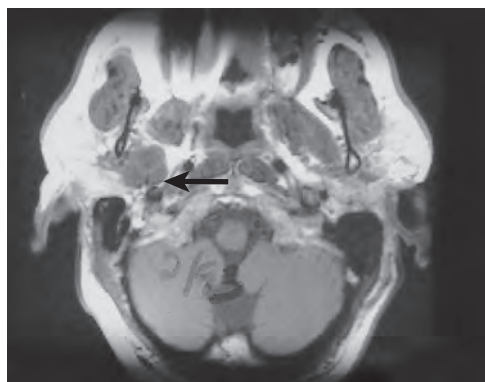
A T2-weighted magnetic resonance imaging scan showing a benign mixed tumor in the superficial lobe of the left parotid gland (arrow).
